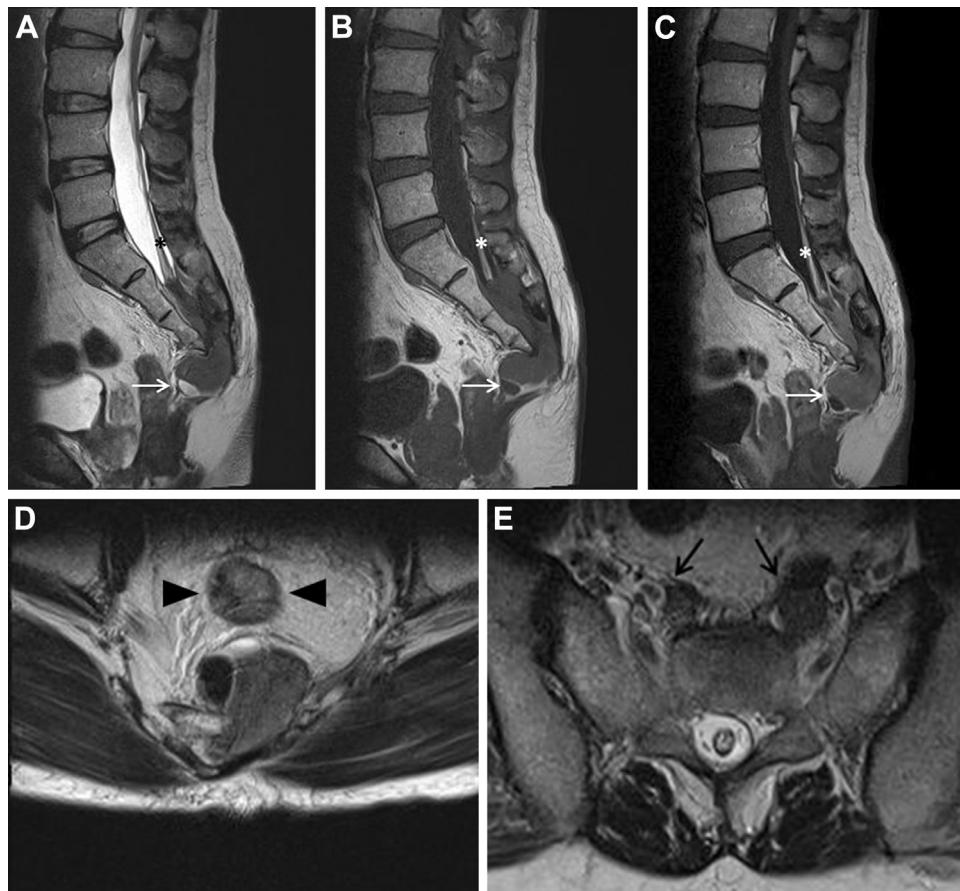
Sagittal magnetic resonance images (*upper panels*) revealing a tumor occupying the extradural space of the sacral spinal canal and caudally extending into the presacral space with cystic components (arrows). The tumor invades into the dural sac and connects with a thickened filum terminale (asterisks), which is tethering the spinal cord. The tumor shows low intensity both on (A) T2-weighted and (B) T1-weighted images. (C) Most of the tumor homogeneously uptakes contrast and the walls of cystic components are strongly enhanced on Gd-contrast T1-weighted image. (D) Axial T2-weighted images show the tumor expanding into the fat tissue around the rectum (arrowheads) through the sacral hiatus and (E) the enlargement of presacral lymph nodes (arrows).
